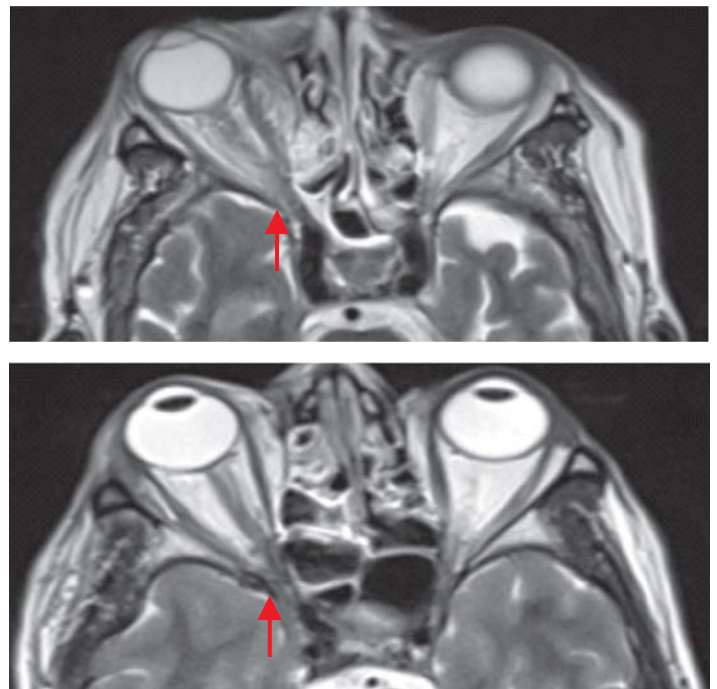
MRI showing orbital apex involvement and cavernous sinus extension (Image courtesy: Dr Seema Sud, Dr Salil Bhargav)
